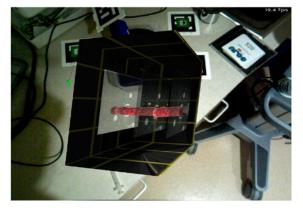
After map generation, the map may be edited to eliminate artifactual structures or to allow the user to identify one anatomic structure among many on which they wish to focus. During editing, the model is presented and slowly rotated directly in front of the user along with ultrasound image slices recorded during the scan. When done the model 'flies' back to its anatomic location within the patient and loses the ultrasound image slices and the grid seen in this image.
